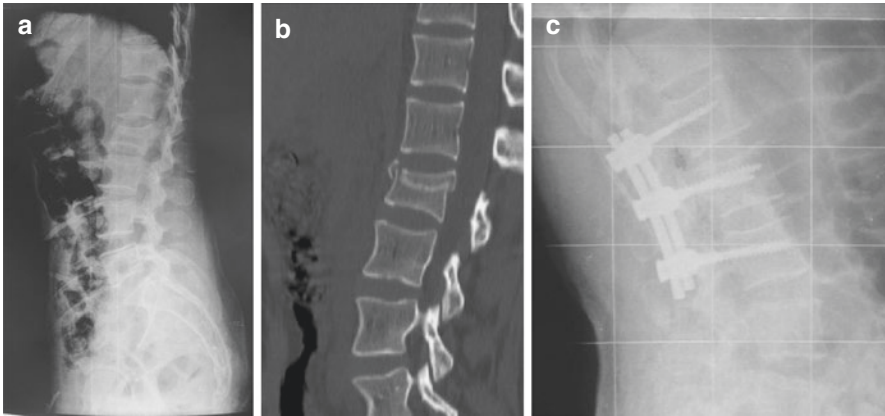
A 32-year-old female admitted to the hospital after traffic accident. Her direct lateral X-ray examination (a) revealed a wedging because of collapse of upper endplate at L2 level. Sagittal 2D reformatted CT scan images (b) showed an AO Type-A3 (incomplete burst) fracture at L2 vertebra. After discussing treatment options with the patient, posterior short segment instrumentation procedure was decided for early ambulation (c)
